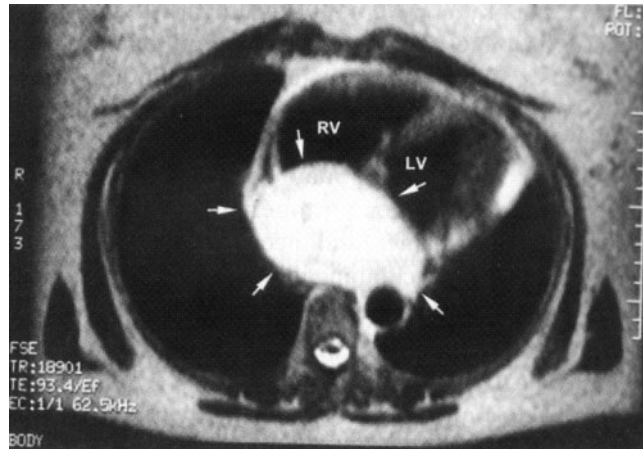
Axial T2-weighted magnetic resonance image showing high signal mass of left atrial hemangioma. (Reproduced with permission from Lo JJ, Ramsay CN, Allen JW, et al: Left atrial cardiac hemangioma associated with shortness of breath and palpitations. *Ann Thorac Surg* 2002; 73:979.)
